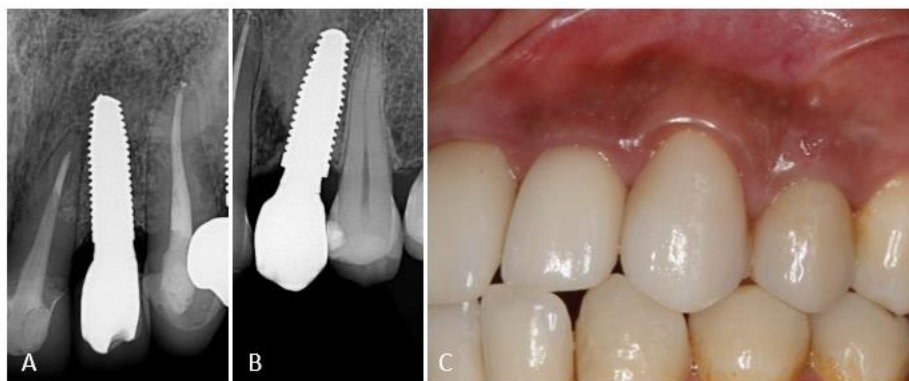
Radiographic (A-B) and clinical (C) aspects after two years of follow-up. Bone level maintenance great soft tissue esthetics were observed.
